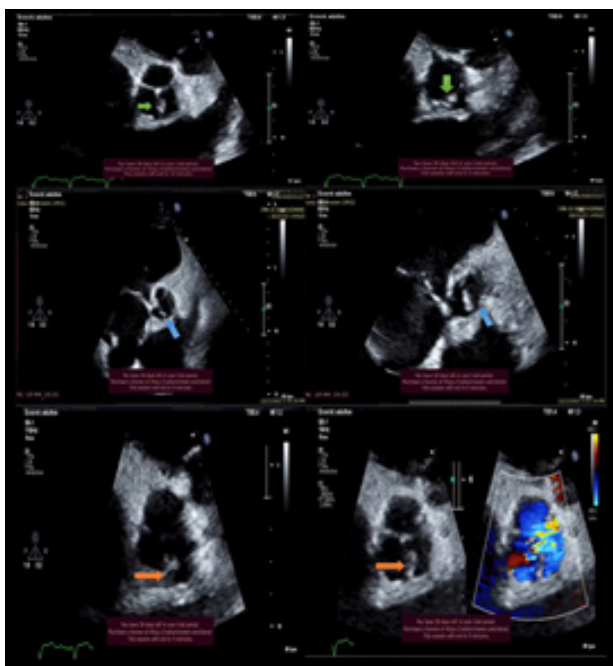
Transesophageal echocardiography (TEE) image with a short parasternal axis of the aortic valve
